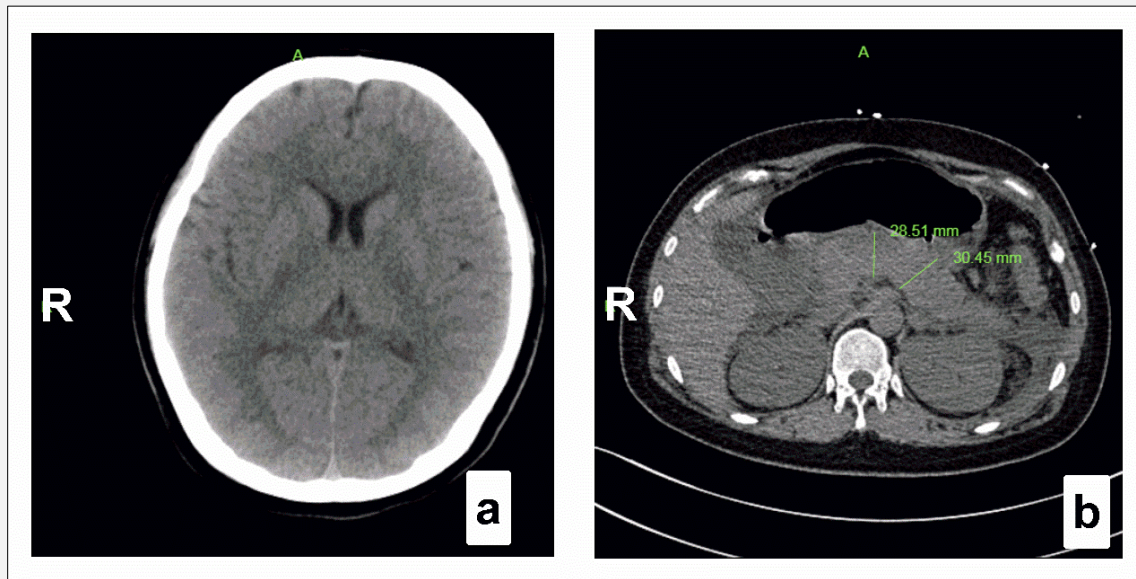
a) Brain CT scan results in cross section. b) CT scan results of abdominal pancreas in cross section.
